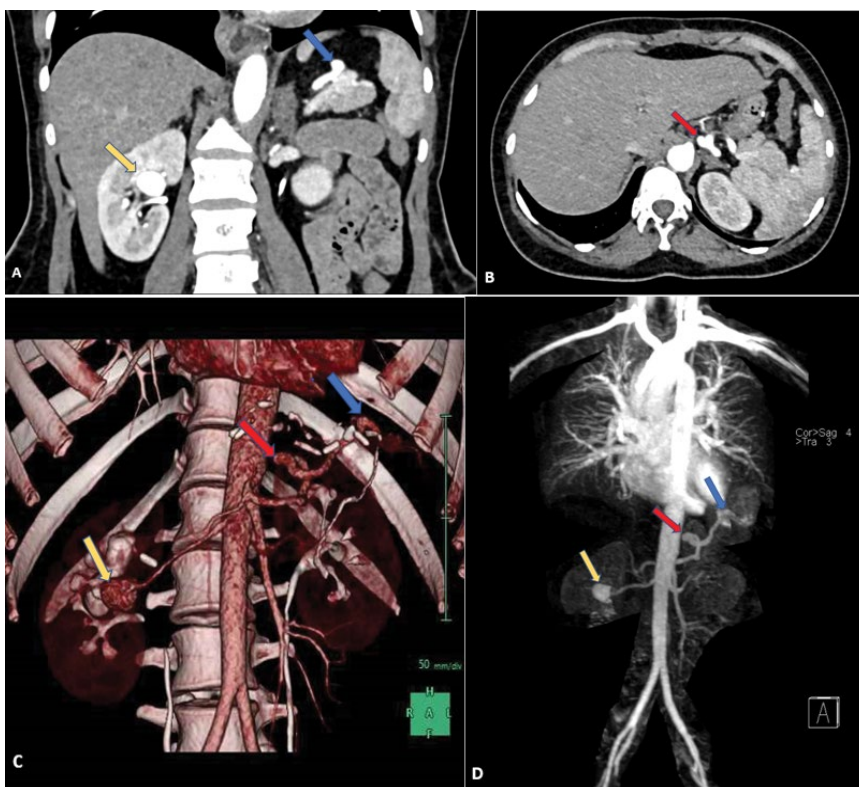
A 40-year-old female with FMD presented with right-sided loin pain and hypertension. A CT with contrast was conducted to assess for vascular anomalies. A shows a coronal image, B is an axial image, C is a 3D reformat C, and D is an MRA of the thoracic and abdominal aorta, showing a right renal artery sacular aneurysm in the right renal hilum (yellow arrow), splenic artery sacular aneurysm at the mid-level of the tortuous splenic artery (red arrow) and fusiform aneurysm in the distal splenic artery (blue arrow). This is part of the many cases that are often misdiagnosed simply because FMD does not appear with the classic multifocal string of beads appearance.
